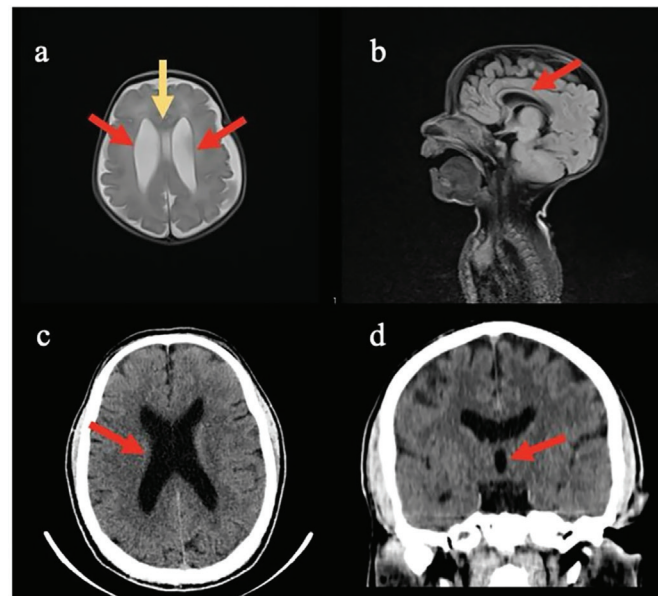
MRI findings of Patient 7. Widened lateral ventricles (indicated by red arrows) and a cavum septum pellucidum vergae variant (highlighted by a yellow arrow) were observed (a). Corpus callosum hypoplasia (red arrow) was seen in the sagittal section (b). CT imaging of Patient 8. The ventricular system and sulci appeared widened (red arrows), indicating cerebral atrophy (c, d). Additionally, a diffuse decrease in periventricular white matter density was observed, consistent with chronic ischemic changes (d)
